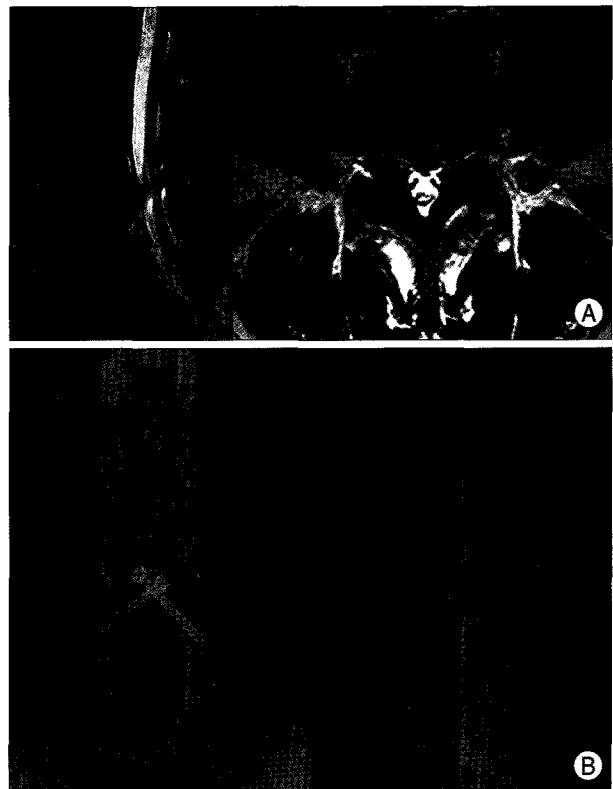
T2-weighted MRI (A) and plain radiographs (B) 2 years after ALIF with PFF demonstrating the restoration of disc height and solid fusion of the L4-5 segment.
